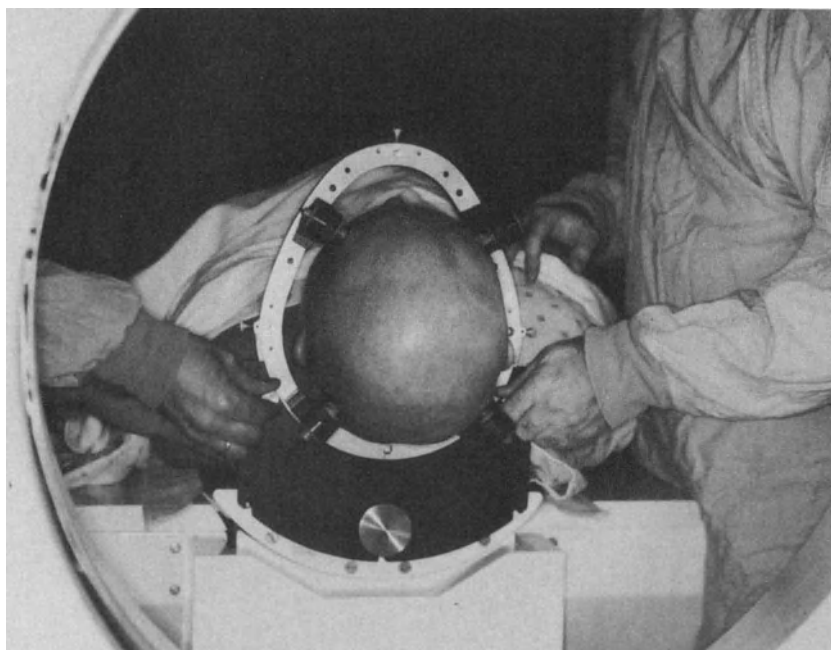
CT scan table adaptation plate receives stereotactic headholder.
